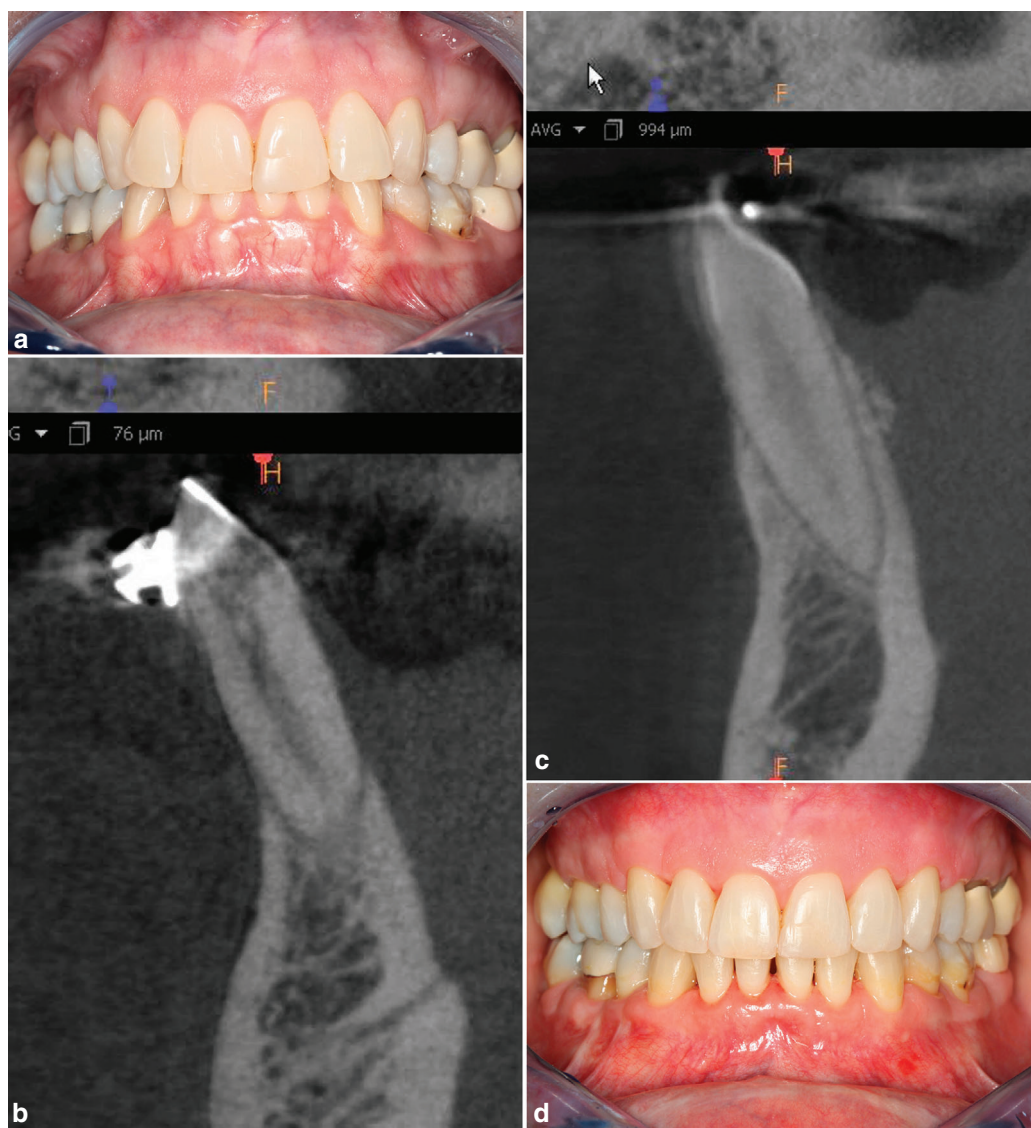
This is a SFOT case with a 10 + years. Follow-up. 3a) pre-op view. (note the “corrugated appearance” because of root prominences for the anterior teeth); 3b) CBCT of the lower anterior segment. (note the lack of supporting alveolar bone); 3c) post-op CBCT of the same area 14 mos. after SFOT; and 3d) clinical presentation after 10 + year. The “corrugated appearance” of the facial alveolar bone, seen in the pre-treatment image no longer evident in the post treatment clinical vies, because of bone augmentation. The orthodontic treatment did not result in the appearance of gingival recession.
